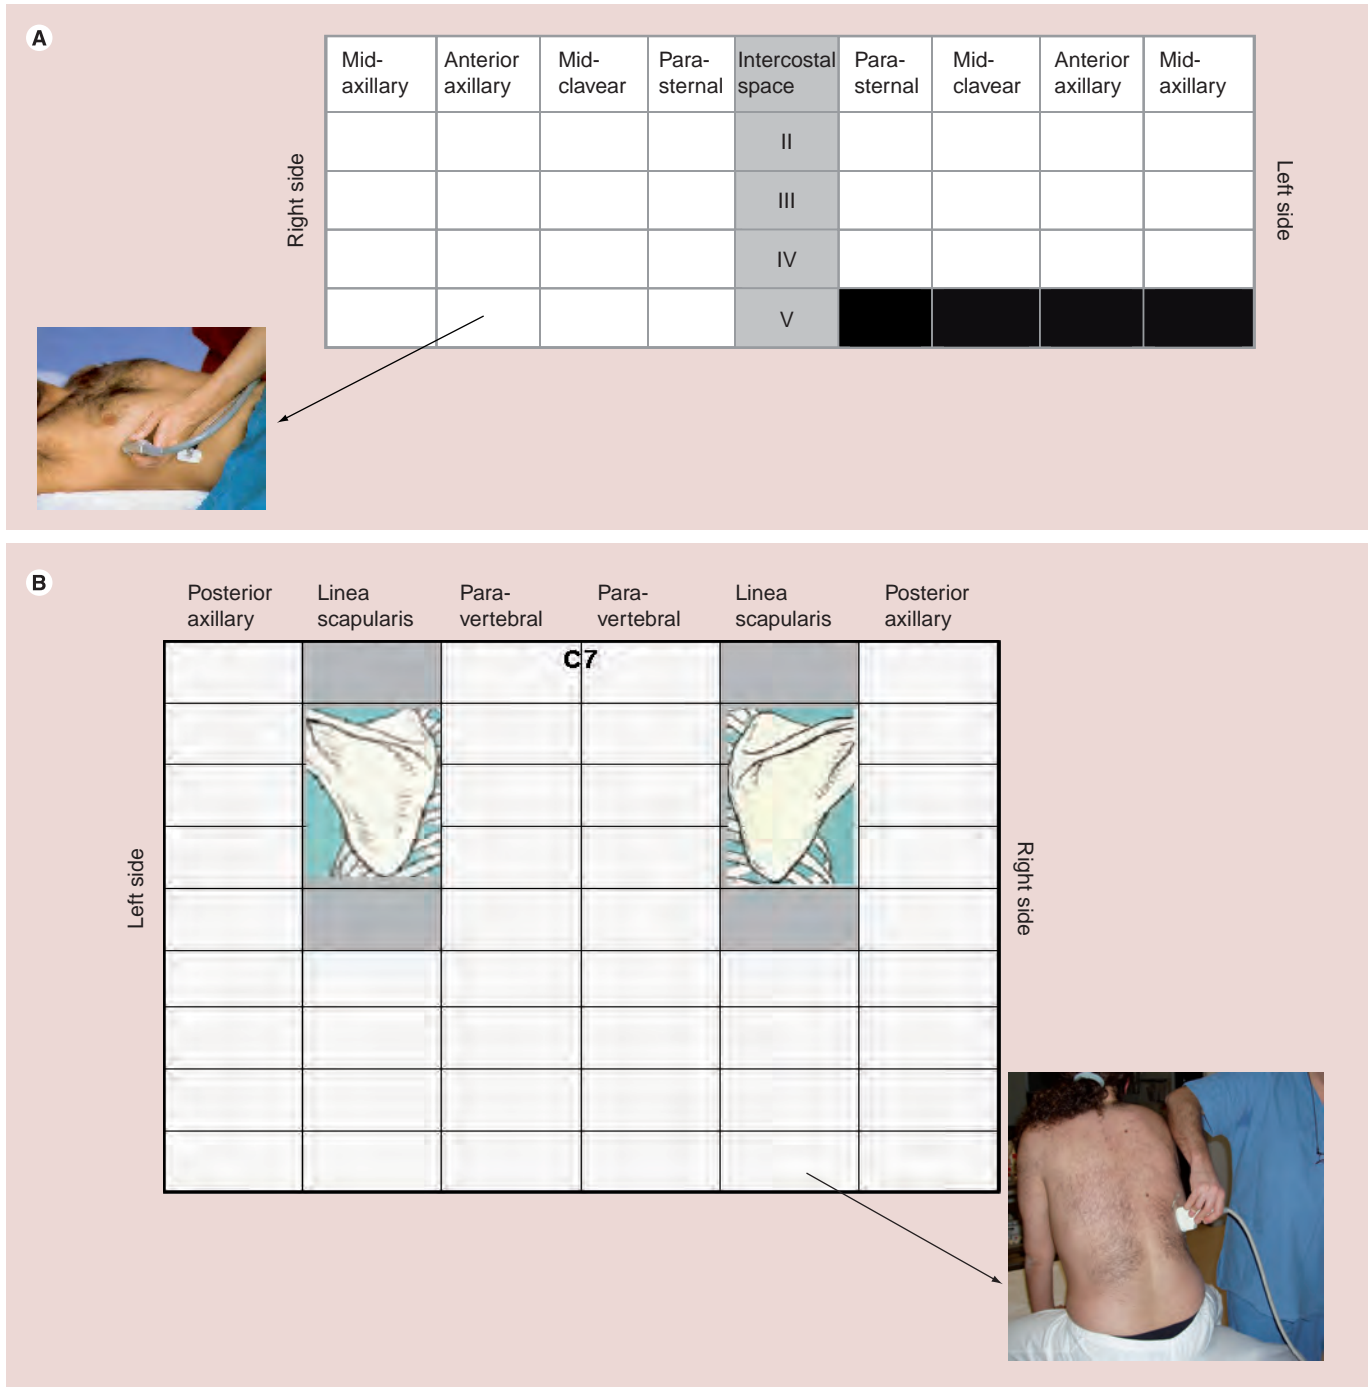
Methodology of lung ultrasound scanning on anterolateral (A) and posterior chest (B). Modified with permission from [33,35].
